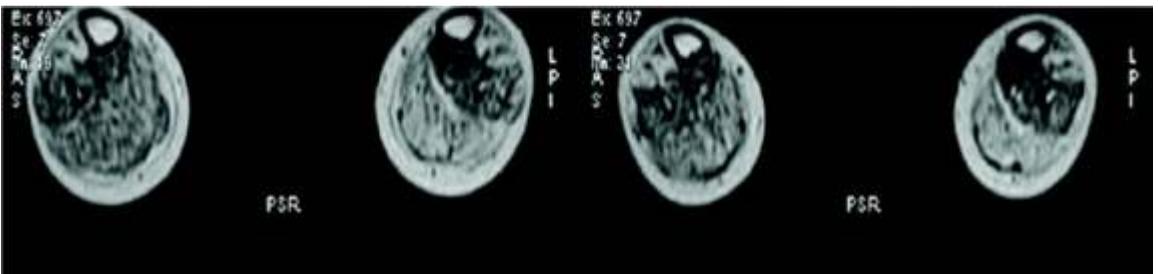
T1 weighted axial musculoskeletal MRI images of Gastrocnemius and Soleus 6 months after Autologous BMMNCs transplantation; arrows showing muscle regeneration and reduced fatty infiltration
